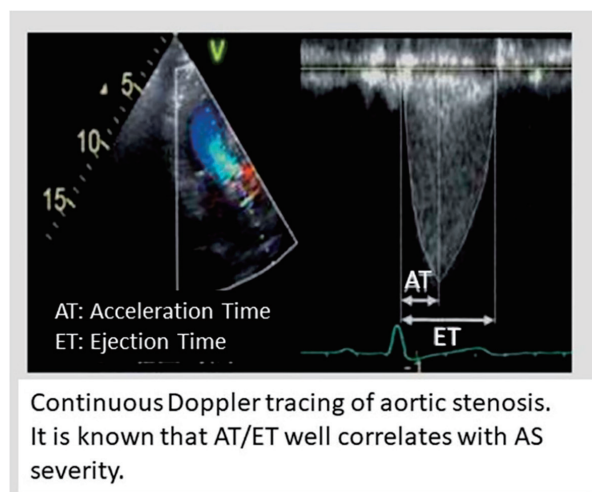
Continuous Doppler record of AS. (from “Researcher Information of the Health Sciences Booklet, Yamaguchi University Graduate School of Medicine” 2023)
